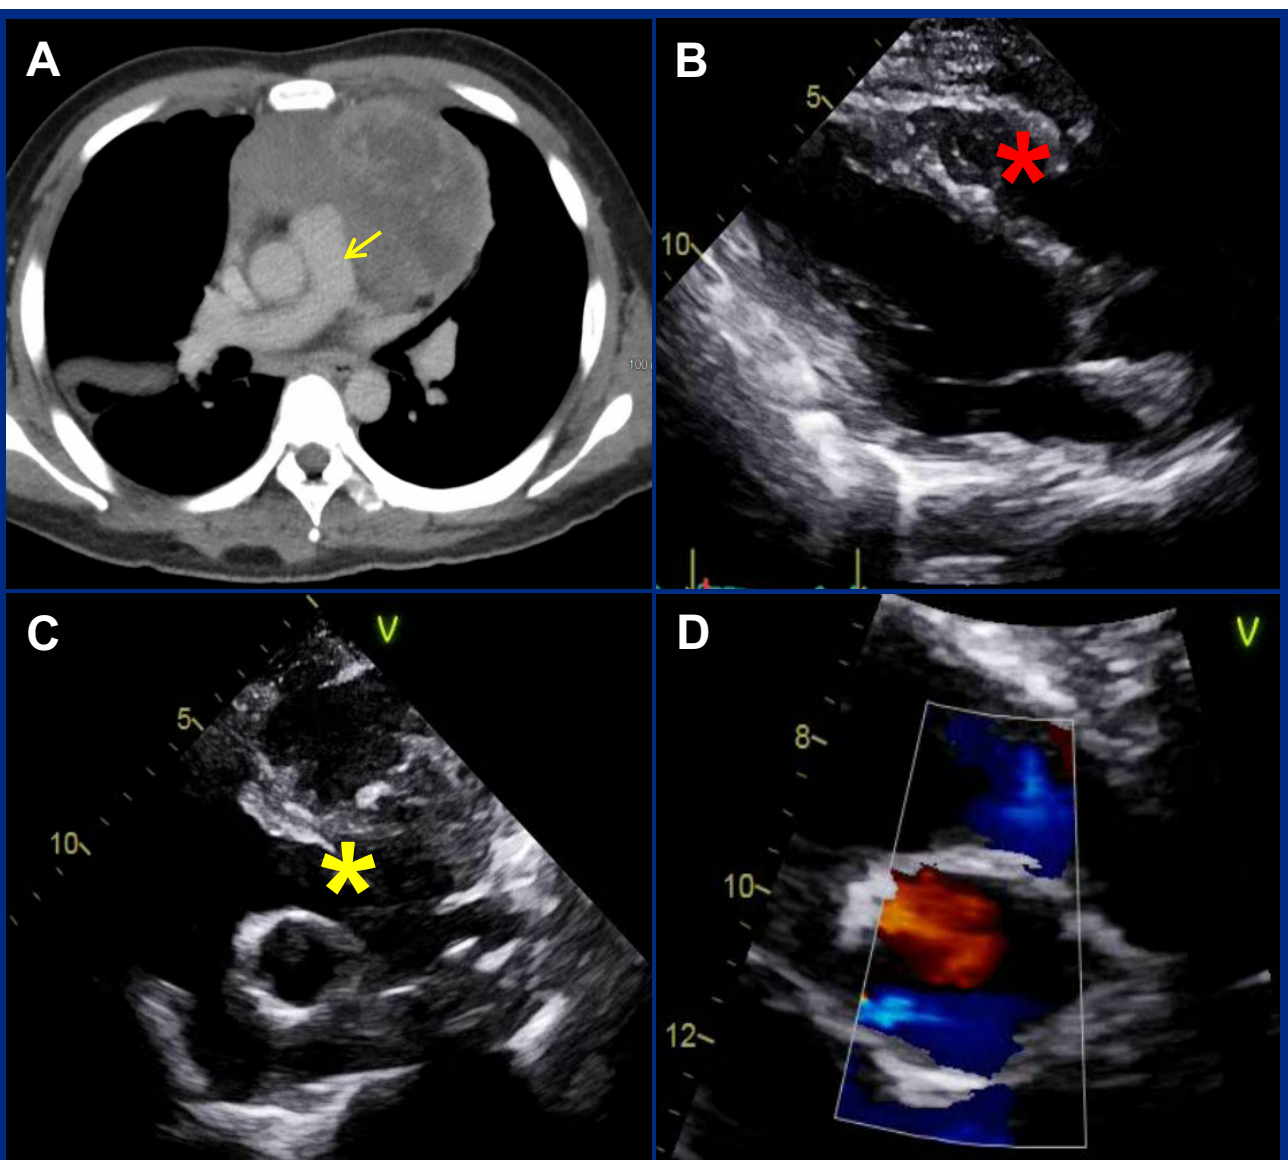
A. CT chest with contrast showed reversal of pulmonary artery stenosis after one cycle of AIM. Post-chemotherapy TTE without dilation of right ventricle (B), reversal of pulmonary stenosis (C), and normal velocity within pulmonary artery and RVOT (D).
